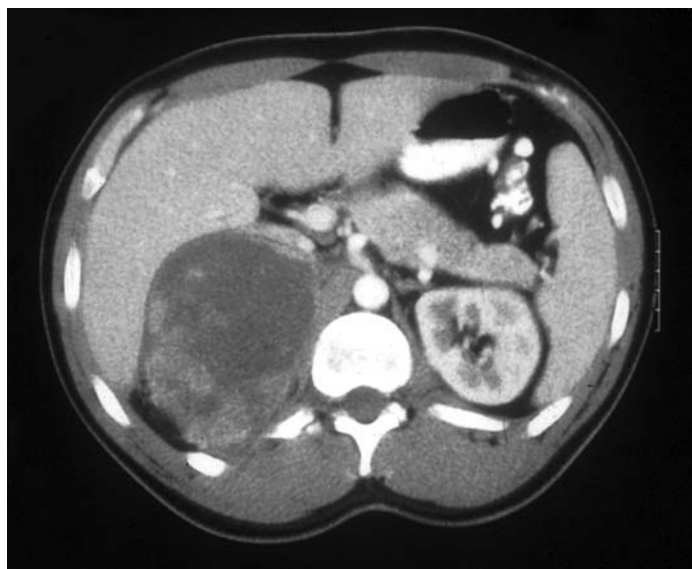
CT scan of a 65-year-old man with a large retroperitoneal leiomyosarcoma clearly demonstrates close association of this mass with the right hemiliver, as well as displacement of the inferior vena cava.
